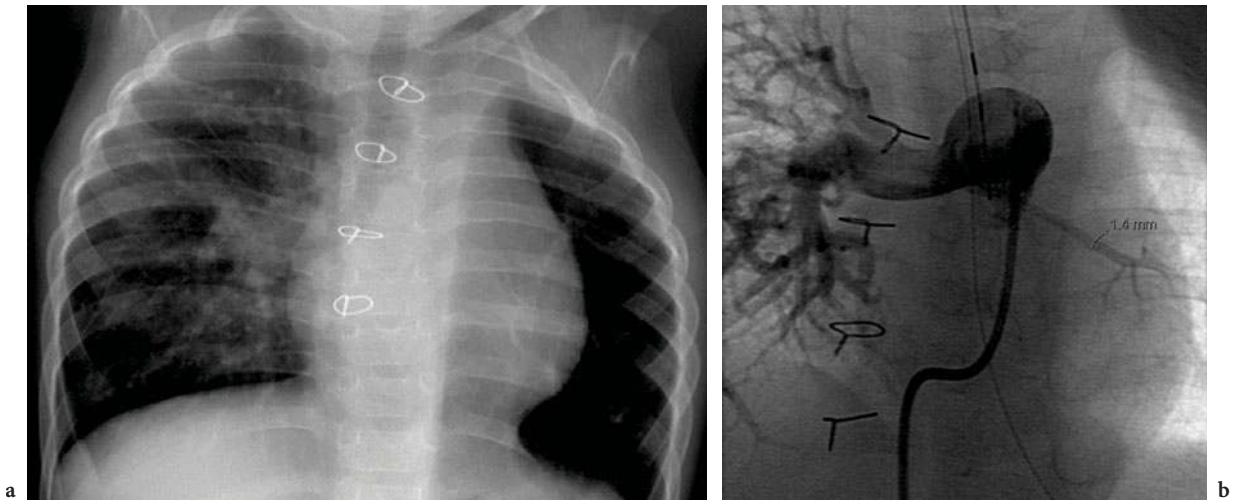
A 14-month-old boy with hypoplasia of the left lung. Chest radiograph shows small left hemi-thorax and very small lung vessels. Angiography with injection of contrast medium into the main pulmonary artery shows large vessels in the right lung, and only one very small branch to the left lung
